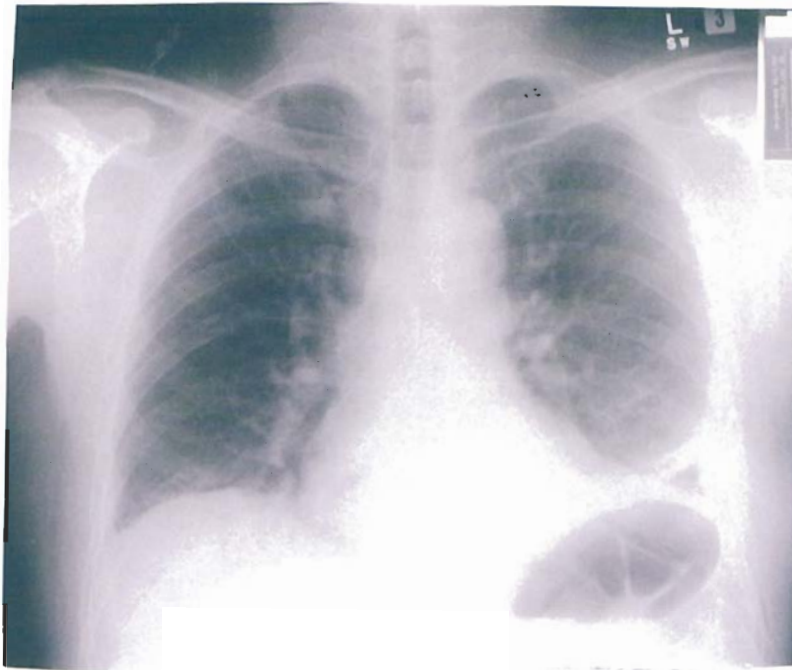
Short history of three months before diagnosis in March 1995. The lateral view shows the mass in the posterior chest which is obscured by the small effusion on the other view. Treated April 1995. X-ray taken on 28 April 1995.
